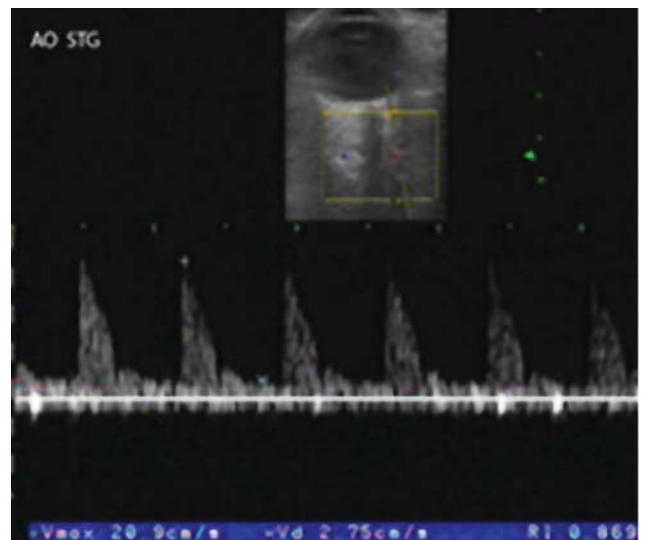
a, b. Patient MM-Spectral Doppler analysis of ophthalmic arteries (OA).
